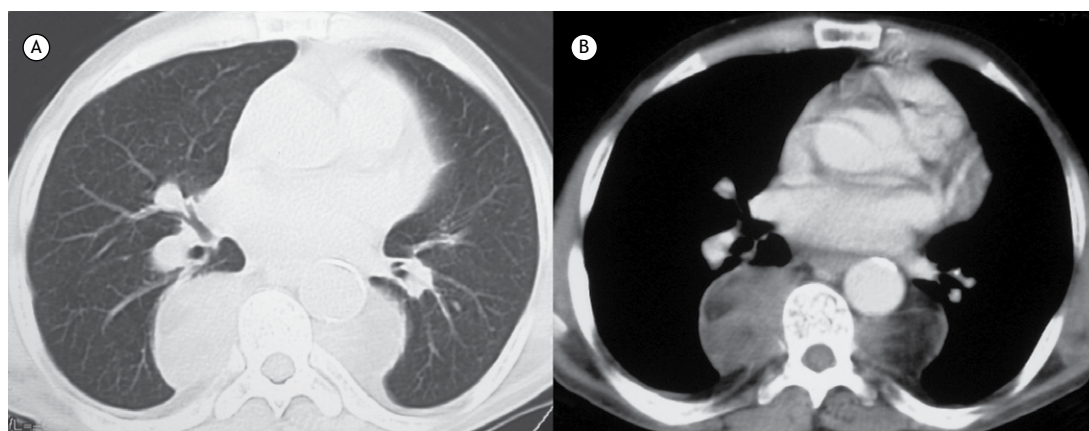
Chest CT scans with lung window (in A) and mediastinal window (in B) settings showing bilateral masses in the inferior paravertebral thoracic regions. The masses were heterogeneous, with low density areas, suggesting a fatty component. The lung parenchyma showed no abnormalities. There is also a large splenic calcification (not shown).
